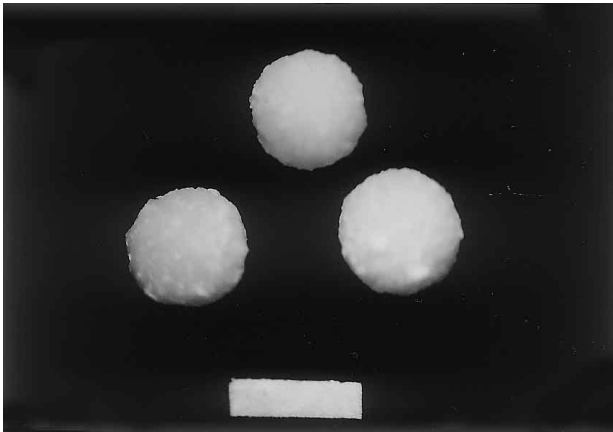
Photograph of Alg-Ca Containing 5% CT
